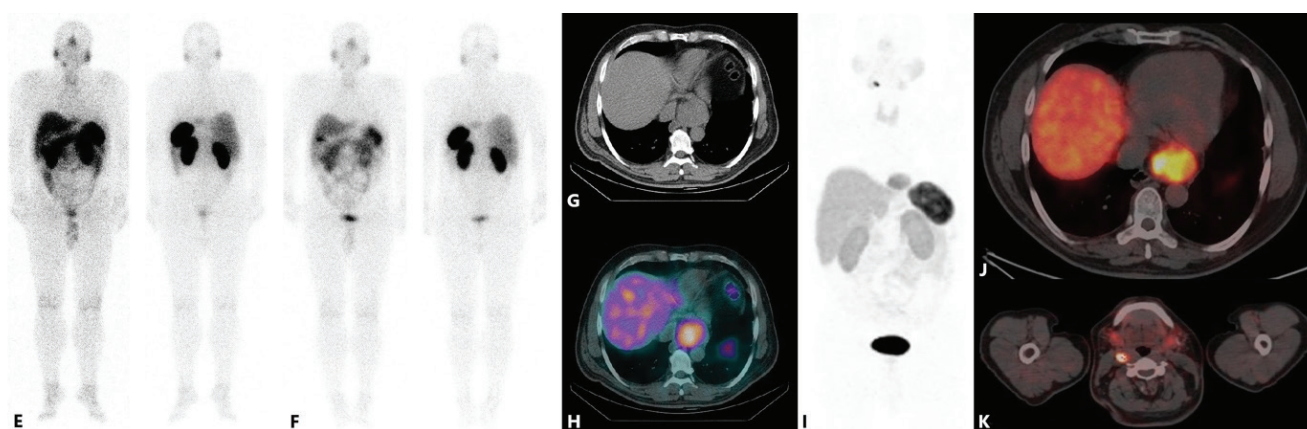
Following embolization of the feeder branch using particles and four cycles of peptide receptor radionuclide therapy (PRRT) with lutetium-177 DOTATATE (¹⁷⁷Lu-DOTATATE) [whole-body scans after PRRT, (E) for first cycle and (F) for fourth cycle]. After 4 cycles of ¹⁷⁷Lu-DOTATATE, computed tomography (CT) (G) and single photon emission tomography/CT axial fusion (H) images of mediastinal mass. After treatment uptake of cervical lesion was decrease while mediastinal mass uptake was stable. Post-PRRT gallium-68 DOTATATE positron emission tomography/CT [⁶⁸Ga-DOTATATE PET/CT] maximum intensity projection (I) and axial fusion (J and K) images of mediastinal mass and cervical lymph node. ⁶⁸Ga-DOTATATE PET/CT imaging in March 2025, 9 months following to fourth cycle, showed partial decreased in tracer avidity with in cervical lymph node [maximum standard uptake values (SUV_{max}): decreased from 56.56 to 33.19; Krenning score of 4 to a score of 3]. Mediastinal mass was stable (SUV_{max} minimal decreased from 18.34 to 17.49; Krenning score of 3 to a score of 3). According to PERCIST criteria, the patient classified stable disease. The serum norepinephrine decreased from 432 to 282 nmol/L after 4 cycles. The patient's symptoms were improved during follow-up. Mediastinal paragangliomas (PGLs) are extremely rare, accounting for approximately 1% to 2% of all PGLs. In patients with inoperable or metastatic PGL, symptomatic or progressive disease is usually treated with chemotherapy, radionuclide therapy, external radiotherapy or tyrosine kinase inhibitors. Functional mediastinal PGLs with anomalous coronary considered high-risk surgically. ¹⁷⁷Lu-DOTATATE therapy is safe modality for inoperable and metastatic mediastinal PGLs. ⁶⁸Ga-DOTA-coupled peptides can be used for imaging because PGLs, which are neuroendocrine tumors arising from pluripotent neural crest stem cells, express somatostatin receptors. Since neuroendocrine tumors overexpress somatostatin receptor like PGLs, ⁶⁸Ga-DOTATATE PET/CT has a high specificity in detecting them. With the use of DOTATATE's theranostic qualities, patients who may be suitable for PRRT can be chosen using ⁶⁸Ga-DOTATATE PET/CT (1-7). This report highlights the role of DOTA-coupled peptides in the diagnostic and therapeutic applications of a rare patient with a mediastinal PGL with an unusual coronary artery supply, which poses a high surgical risk.
